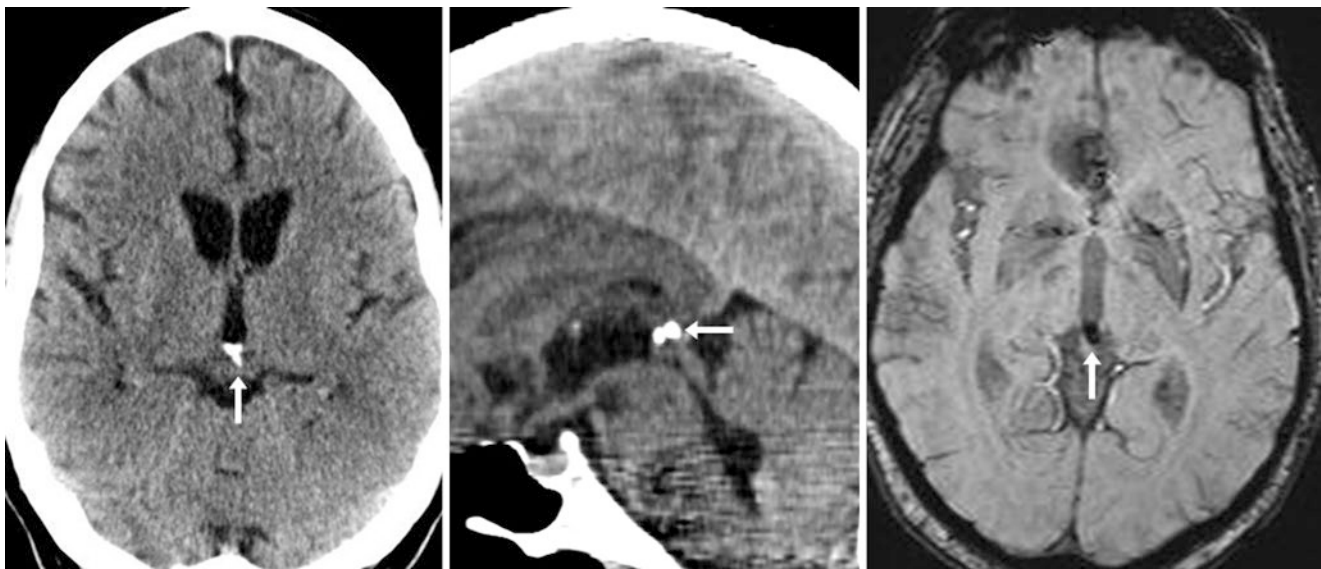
A 67-year-old patient with calcification of the pineal gland (*arrows*) on axial (*left*) and sagittal (*middle*) NECT. This is manifested as a focal region of dark susceptibility artifact on 1.5 T axial SWI MRI (*right*)
